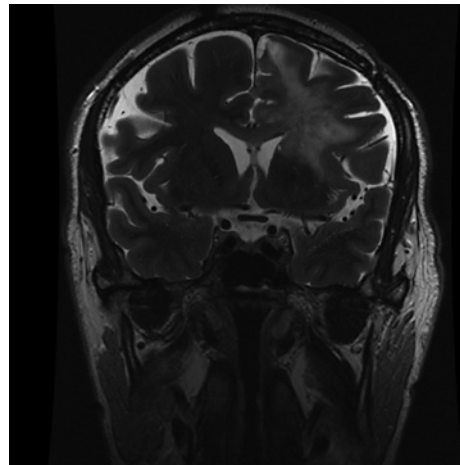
July 2020, MRI coronal T2 FSE, before starting regorafenib treatment.
